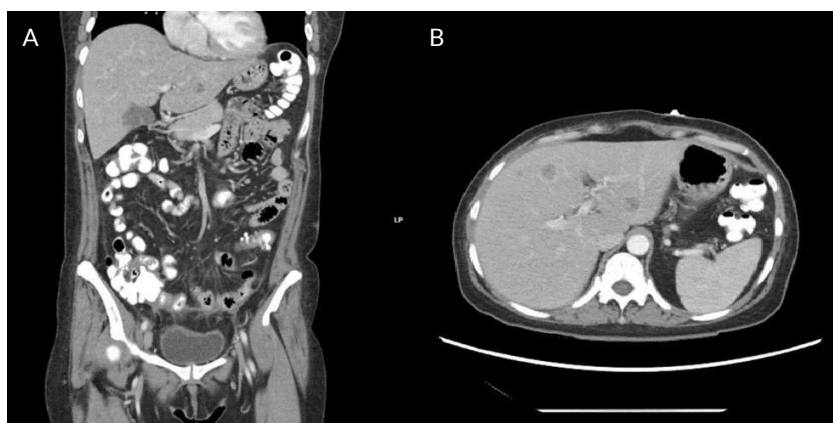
Computed tomography scan of the chest, abdomen, and pelvis at diagnosis confirming metastatic disease to the Liver. A) Coronal plane showing metastatic lesion in the left hepatic lobe and B) Axial plane showing metastatic lesion in the right and left hepatic lobe.
